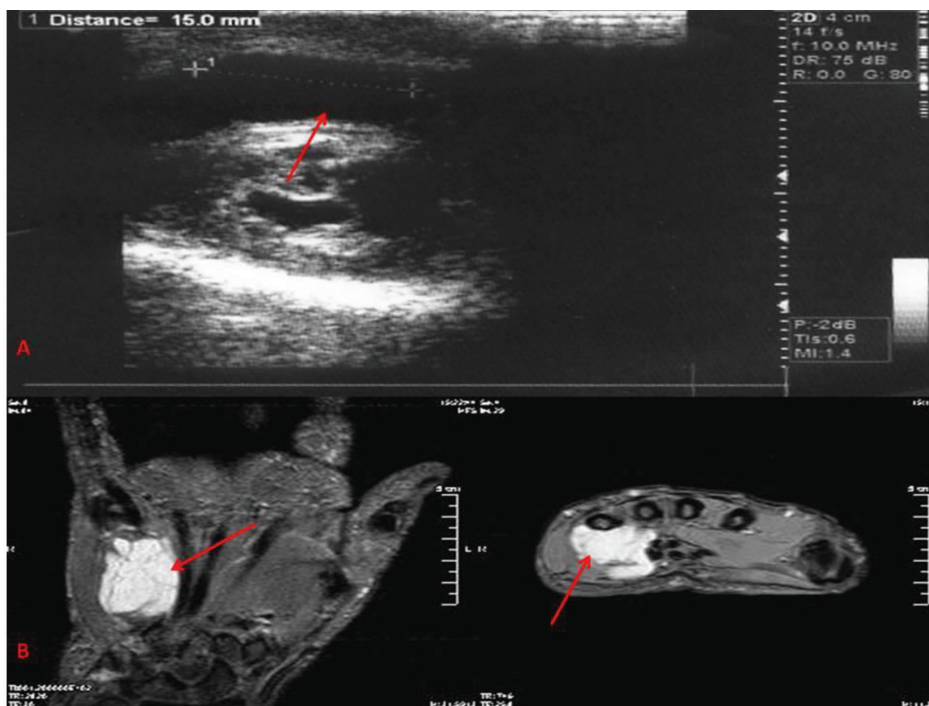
A) Ultra sound (U/S) imaging indicating an hypoechoic, homogeneous mass. B) T2-weighted MRI images reveal a multilobulated mass in the hypothenar area measured about 3,5 cm x 3 cm on coronal plane, and 2,5 cm x 2,5 cm on transverse plane.
